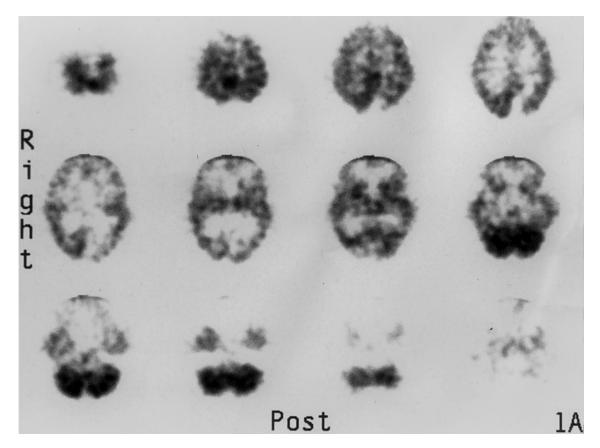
HMPAO SPECT scan of a patient with head injury approximately 3 years prior to the scan, demonstrating a significant perfusion defect in the left medial occipital area extending to the visual cortex on the affected side. This finding corresponded to the clinical feature of a right homonymous hemianopsia (Reprinted with permission from Alavi A, Hirsch LJ: Studies of central nervous system disorders with single photon emission computed tomography and positron emission tomography: Evolution over the past two decades. Sem Nucl Med 21:58-81, 1991).
